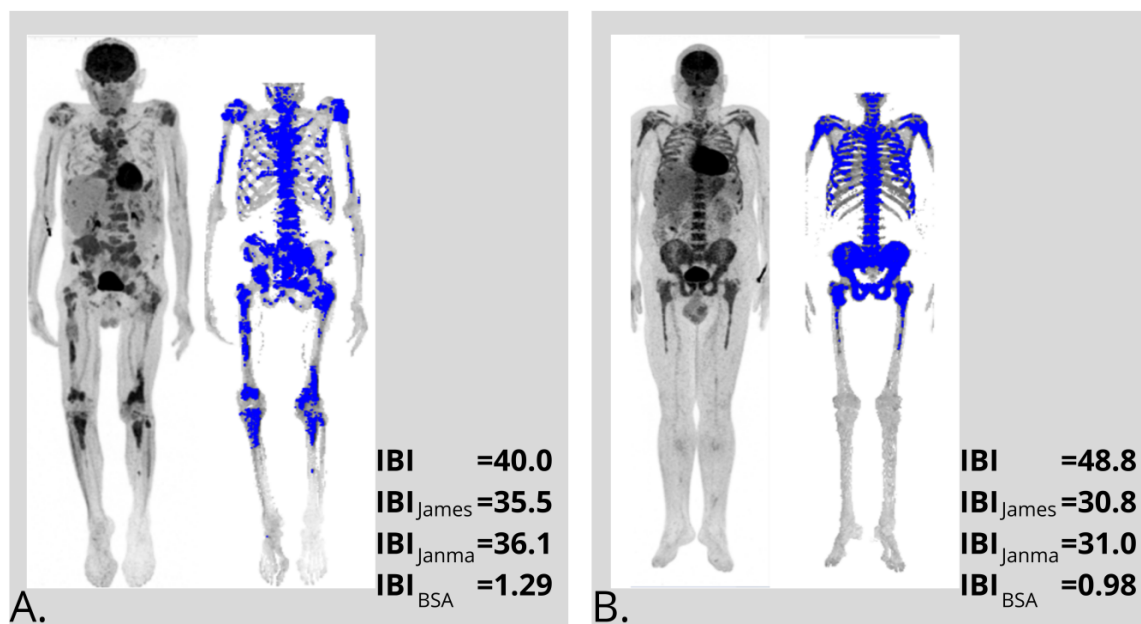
Corrections of Intensity of Bone Involvement (IBI) for two patients diagnosed with multiple myeloma, each exhibiting distinct body weights, both visually categorized with marked bone involvement. IBI was corrected for lean mass (LBM), using the *James* (IBI_{James}) and *Janma* (IBI_{Janma}) models, and for body surface area (IBI_{BSA}). (A) represents a male patient weighing 47 kg (BMI=16.7 kg/m²). (B) features a male patient weighing 116 kg (BMI=41 kg/m²). The left side of A and B displays maximum intensity projection (MIP) from ^{18}F -FDG PET/CT images, while the highlighted blue areas on the right indicate metabolically active regions where ^{18}F -FDG uptake exceeds hepatic uptake. Notably, after LBM and BSA corrections, the patient in B, with a higher body weight and higher standard IBI, presented lower corrected IBIs than the patient on A, who had a lower body weight.
